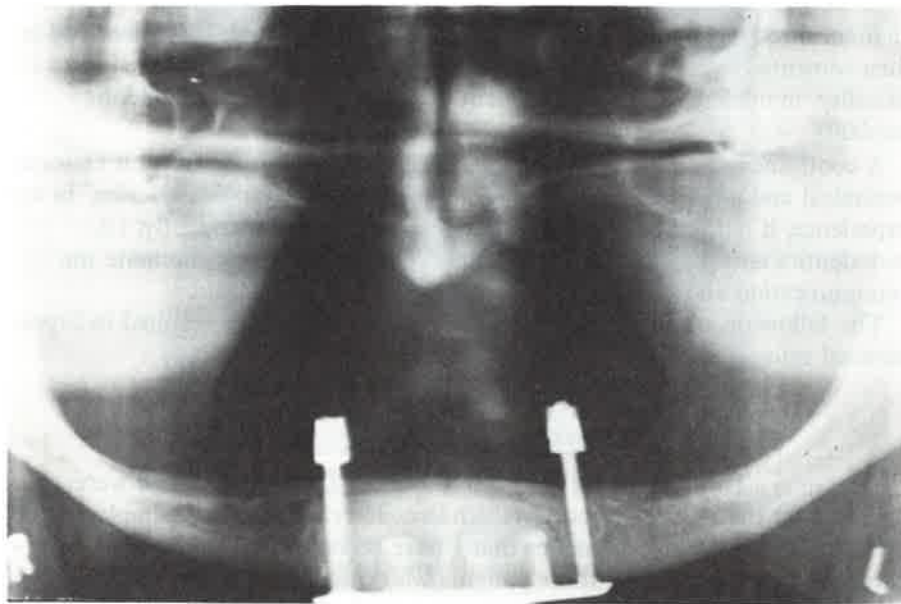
Radiograph of staple mandibular implant in situ.
